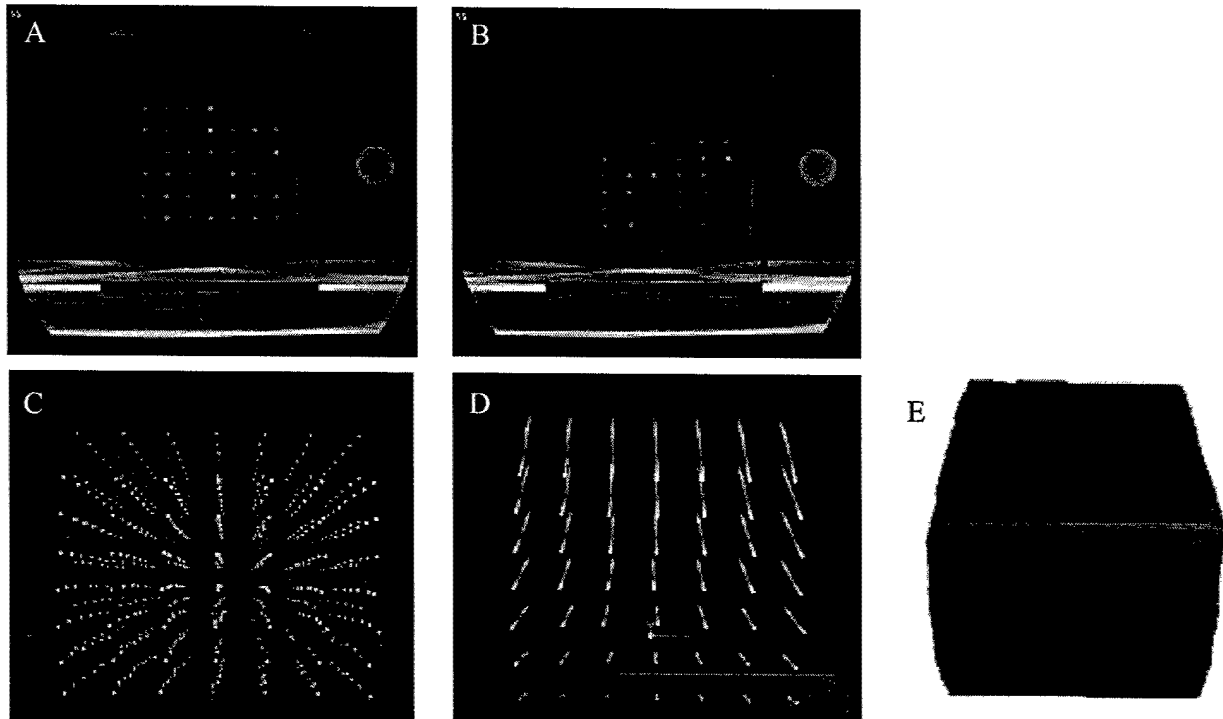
The CT image of the central x - z plane of the "Truth Cube" after segmentation in both the (A) unloaded and (B) maximally compressed states; the upper registration sphere is noticeable in these images. (C) 3_d perspective view of the centroids of best-fit spheres for all 343 beads in all strain states (blue = unloaded, green = 5%, red = 12.5 %, yellow = 18.25% strain). (D) Trajectory of the beads in the x - z central plane of (C). (E) Outer surfaces of the cube in its 4 strain states (purple = unloaded, red = 18.25%).
